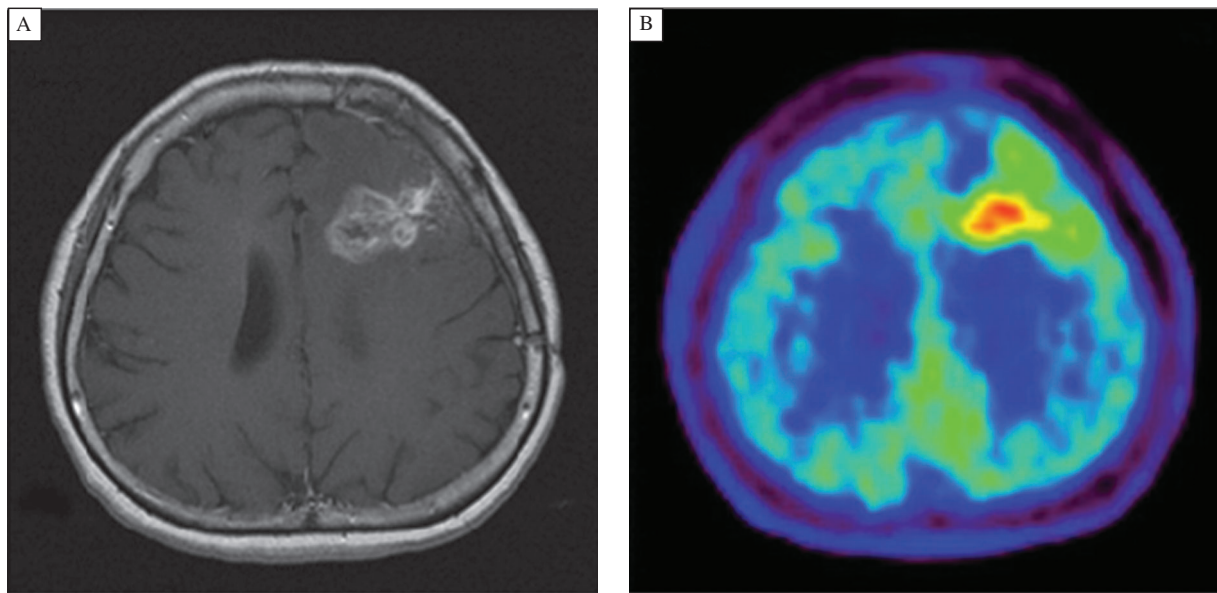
Imaging of 49-year-old woman who had been previously treated for glioblastoma multiforme with tumor resection and conventional radiotherapy at dose of 60 Gy (with permission from reference 18). A: T1-weighted MR image with contrast medium, obtained 13 mo after initial surgery, showing contrast-enhanced lesion in left frontal lobe. B: ^{11}C -Met PET image showing obvious accumulation of tracer corresponding to abnormality on MR image. L/Nmean was 1.70. Recurrent tumor was pathologically confirmed by second surgery.
